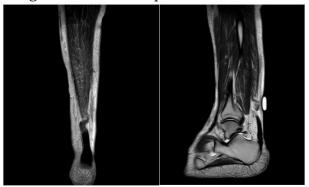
(a,b): MRI ankle coronal and sagittal, Achilles tendon grade II complete tear 6cm from the insertion with gap and mild retraction as described with periarticular soft tissue and subcutaneous contusion.
